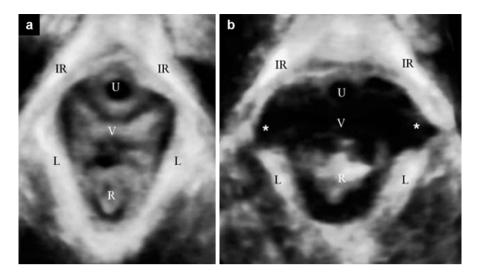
Tomographic ultrasound images obtained using transperineal ultrasound of (a) a typical intact levator ani muscle (LAM) in a nulliparous woman and (b) a bilateral LAM avulsion in a multiparous woman. Slices were obtained at 2.5-mm intervals below and above the level of minimal hiatal dimension (\*). LAM defects are indicated in (b) by \* (Reprinted from Schwertner-Tiepelmann et al. [63]; with permission from John Wiley and Sons
